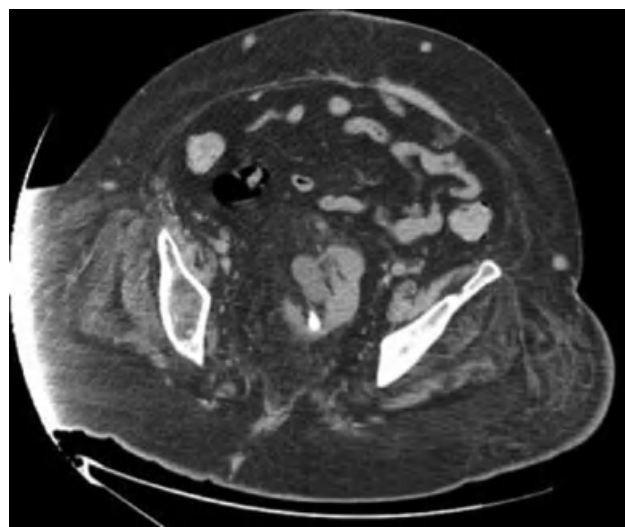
(A, B) CT scan of left pelvic kidney demonstrating aberrant vasculature (arrows).
